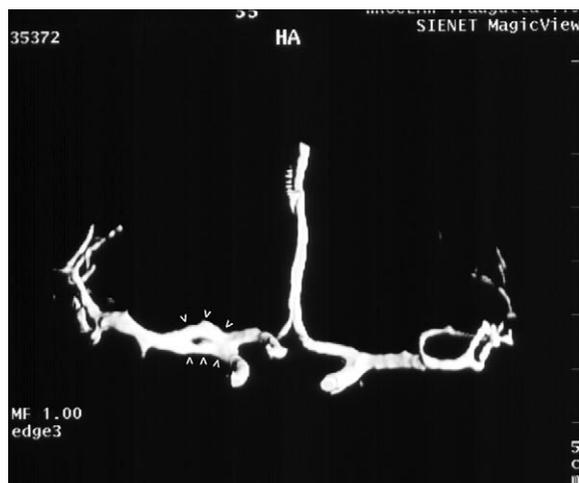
CT angiography (VRT reconstruction) shows fenestration of M1 segment of right MCA (arrows). No aneurysm or other vascular malformation is visible.
